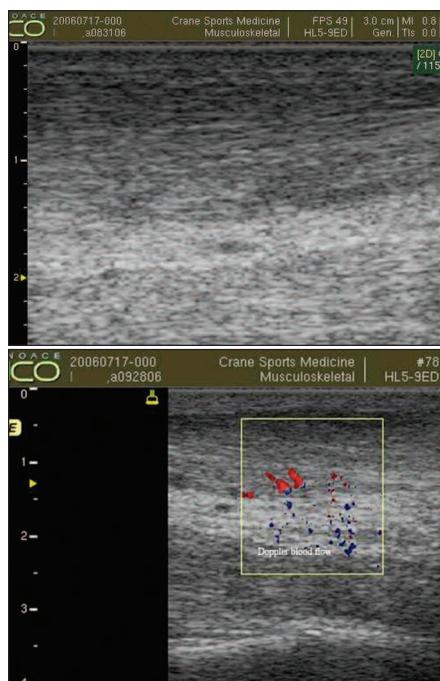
Diagnostic ultrasound of the left Achilles taken 1.5 months after initial PRP matrix grafting showing improved collagen organization, less fibrosis, and improved capillary blood flow.
